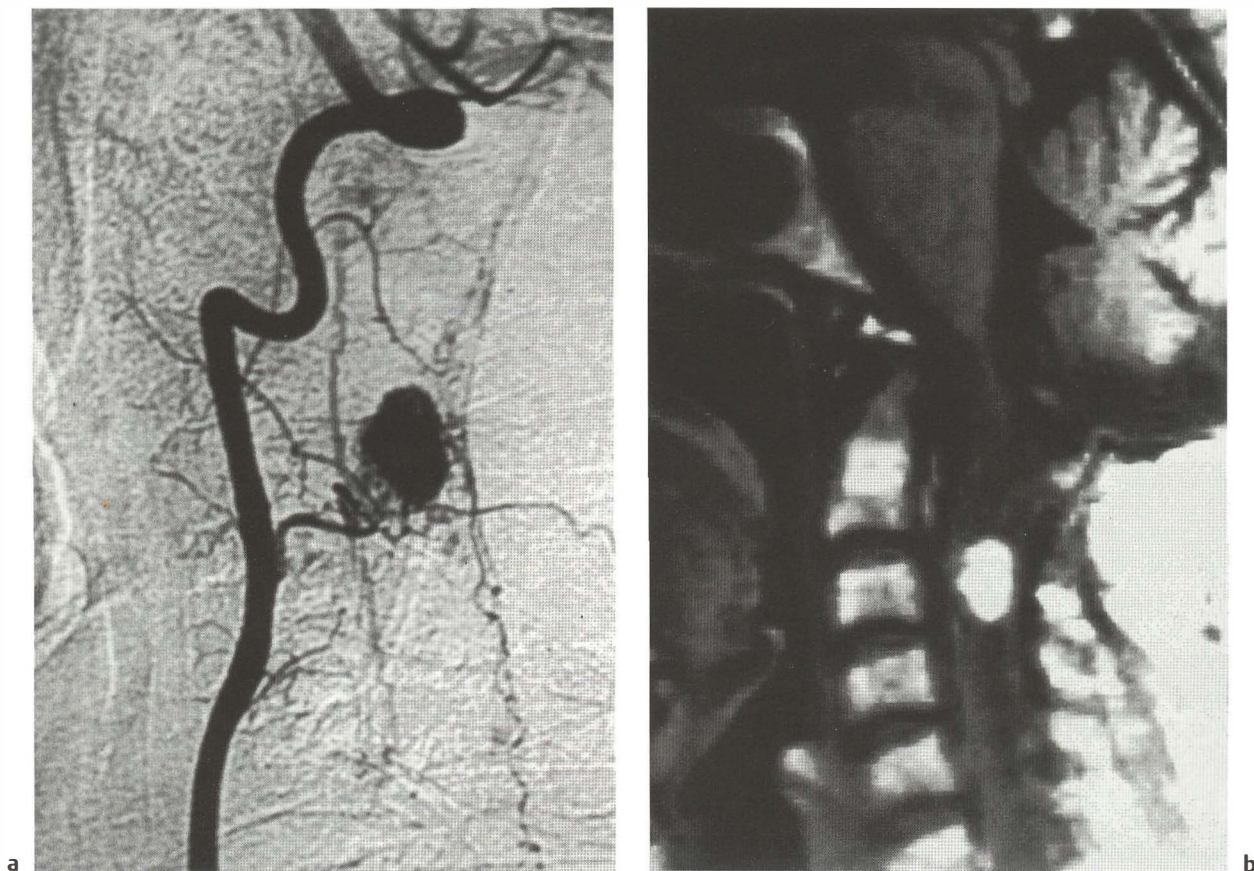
Multiple hemangioblastomas in von Hippel-Lindau disease (case 126) (courtesy of Prof. J.-F. Bonneville, Centre Hospitalier Universitaire, Besançon). a On the vertebral angiogram, a hypervascular nodule can be seen at the level of C3, which enhances on the sagittal T1-weighted postcontrast MR scan (b). c Lower thoracic myelogram: dilated tortuous feeding arteries and draining pial veins that perfectly match the images seen on the spinal cord angiogram (d)
